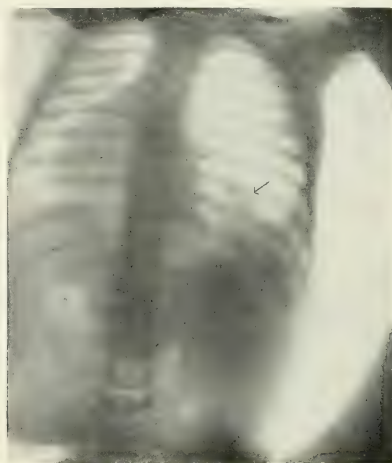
Radiograph showing abscess in right lung due to obstruction of the lower lobe bronchus by a peanut aspirated about one month before. Peanut removed and abscess thus evacuated bloodlessly through the mouth by bronchoscopy.
